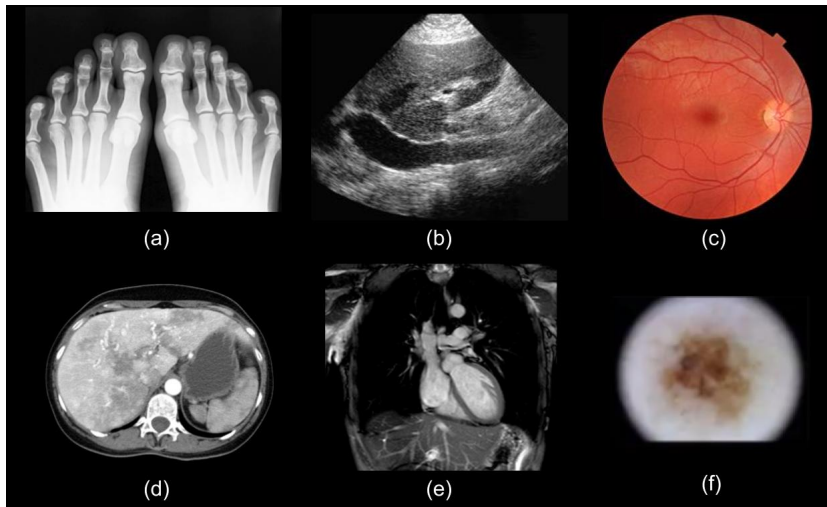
Sample medical images. (a) X-ray of feet (b) Ultrasound of abdomen (c) Optical image of retina (d) CT of liver (e) MRI of heart (f) Optical image of skin lesion
